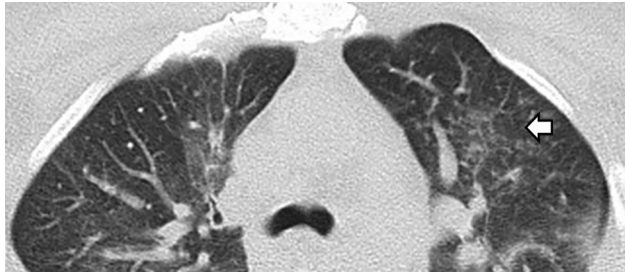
Computed tomography scan of the chest in a patient with *Mycobacterium obuense* pneumonia, Mexico, showing air space infiltration in the left parahilar and a tree bud pattern in the left upper lobe (arrow), as well as bilateral interstitial thickening and ground glass opacities.
